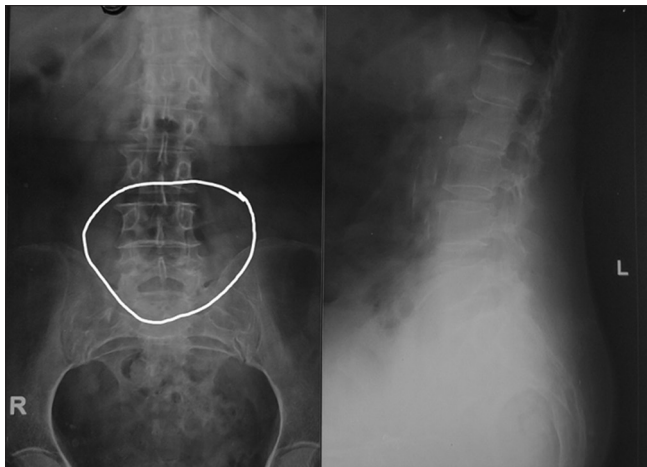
X-rays of lumbar spine (anterio-posterior i.e. AP view and lateral view)
